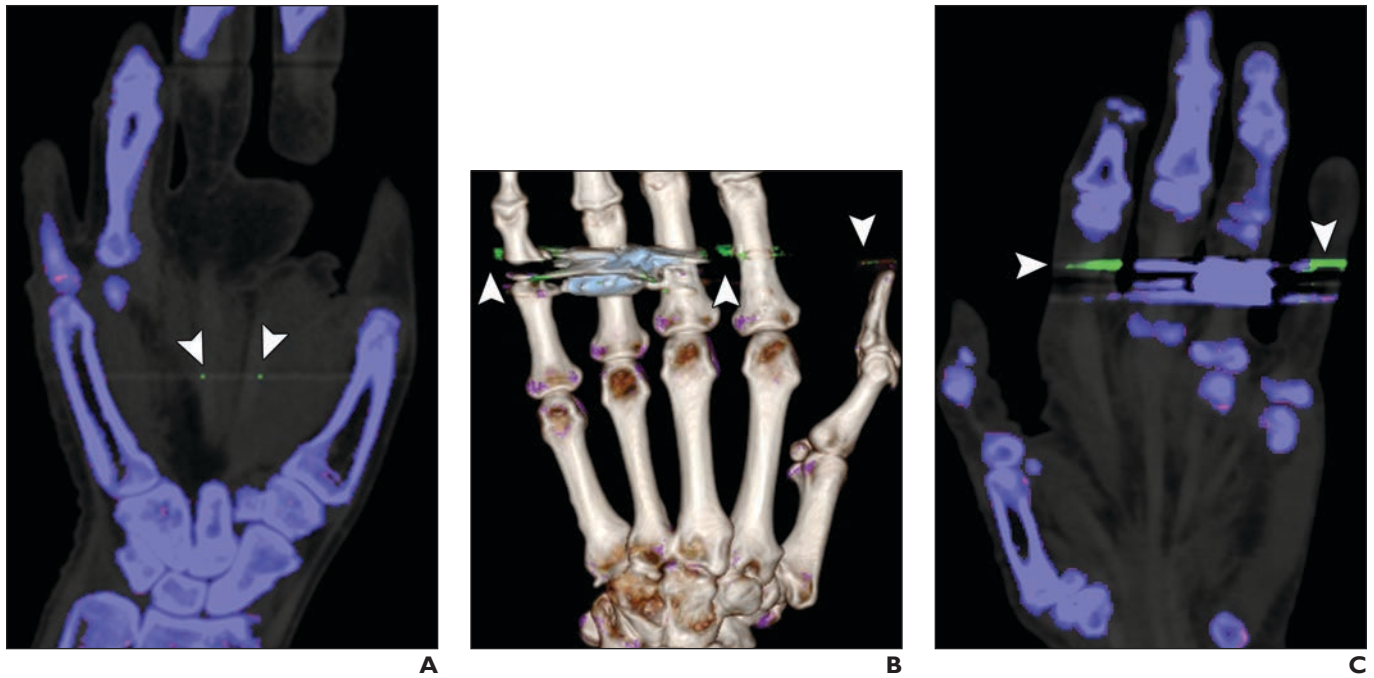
Beam-hardening artifact on dual-energy CT (DECT) images of patients with suspected gout.
